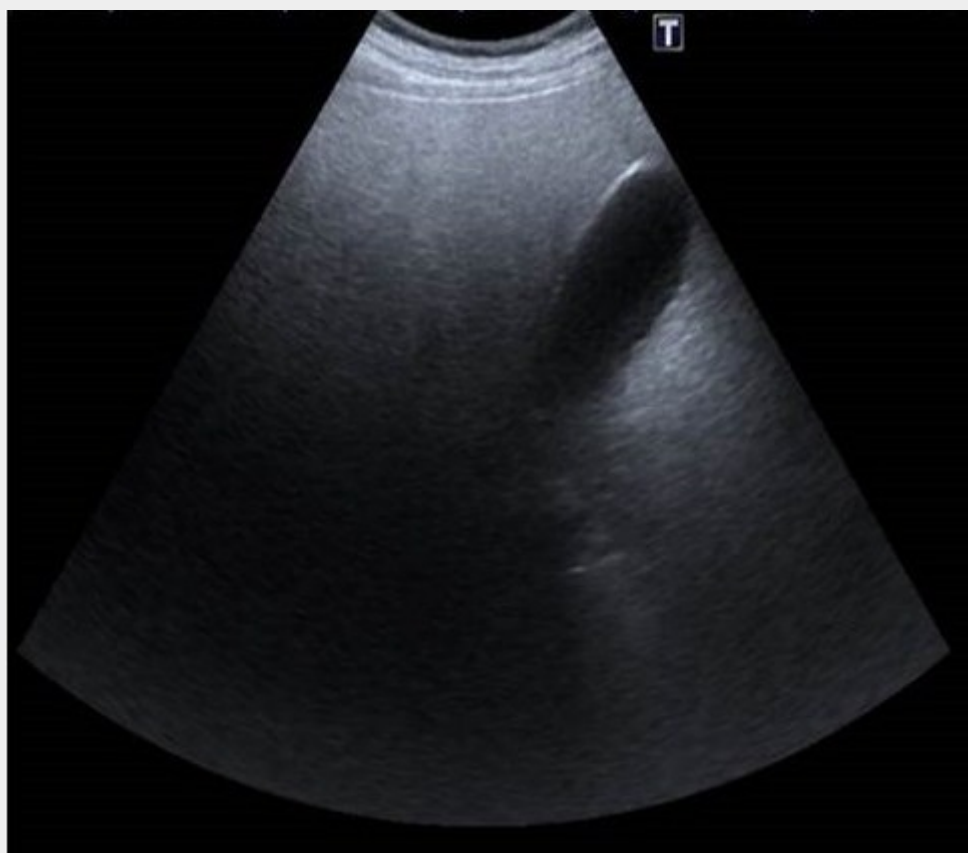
Ultrasound image in a severe case of hepatic steatosis. There is a very high attenuation of the ultrasound beam caused by the diffuse fat infiltration.
